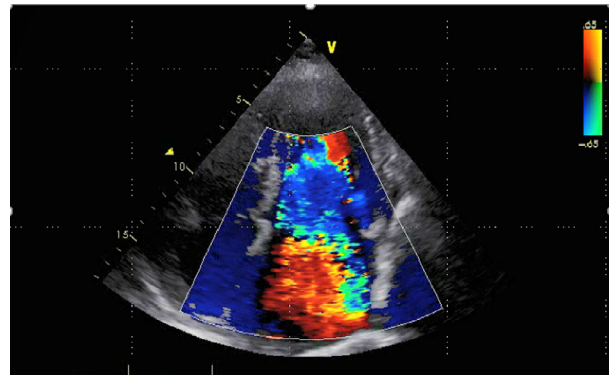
Transesophageal echocardiogram of a 40-year-old man. Severe mitral valve regurgitation with ruptured mitral chordae tendineae was observed.
